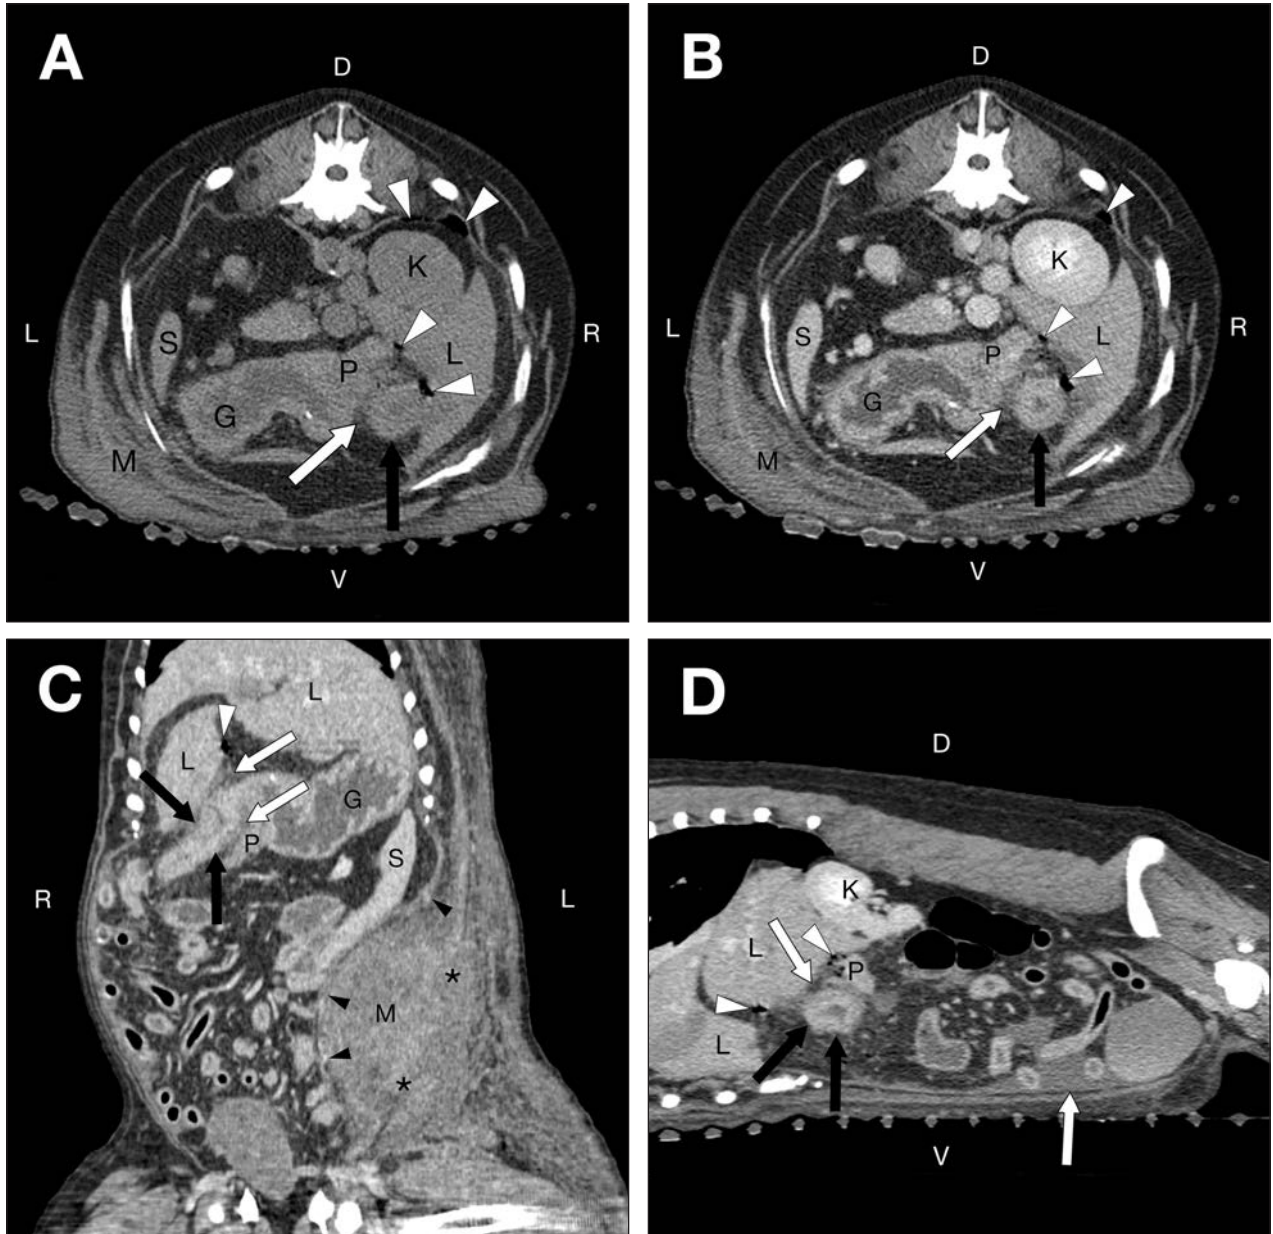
Same abdominal CT images as in Figure 1. On the precontrast (A) and postcontrast (B) transverse images, note the multiple small gas bubbles (arrowheads) adjacent to the thickened duodenum (black arrow), peritoneal fluid (white arrow), and a subjectively large pancreas. A portion of the body wall mass can be seen. The thickened duodenum is more conspicuous after contrast medium administration. On the reformatted postcontrast, dorsal plane (C) and reformatted postcontrast, right parasagittal plane (D) images note multiple hypoattenuating small gas bubbles (white arrowheads) adjacent and cranial to the thickened duodenum (black arrows) and adjacent and caudal to the liver. Most of the peritoneal fluid (white arrows) is observed in the dependent (ventral) aspect of the abdomen, and scant amounts of peritoneal fluid are found in the spaces between the liver and duodenum and the duodenum and pancreas. The mass causes medial deviation of the peritoneum and is peripherally contrast enhancing (black arrowheads). Differentiation between the mass and the abdominal body wall musculature is not possible (asterisks). G = Stomach. K = Right kidney. L = Liver. M = Body wall mass. P = Pancreas. S = Spleen. See Figure 1 for remainder of key.
